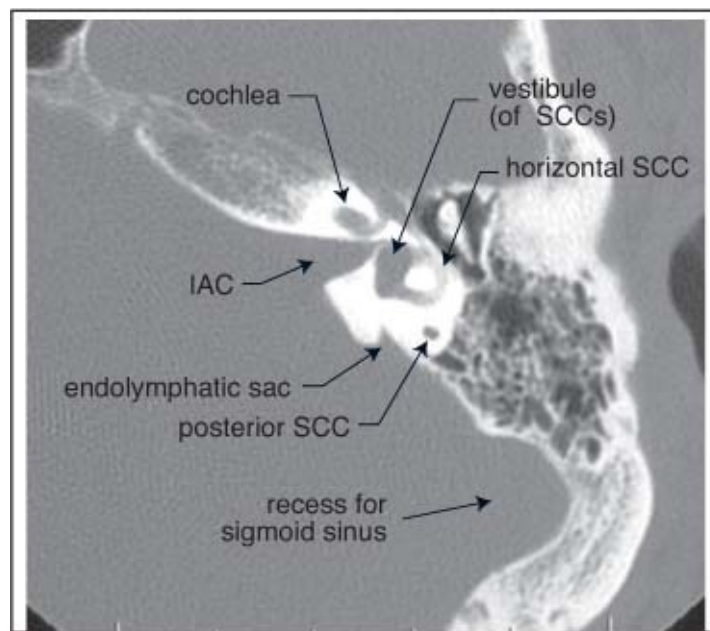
Structures of the left temporal bone. CT scan (left petrous bone, axial slice) provided courtesy of Chris Danner, M.D.
